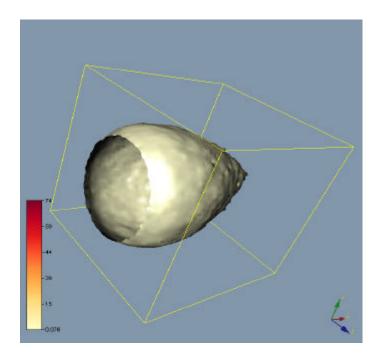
3D Monte Carlo Iso-dose Calculation of the X-ray radiation field
